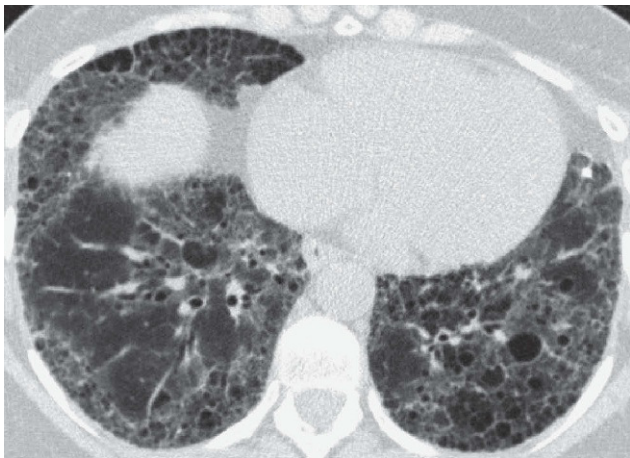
High resolution computerised tomography (HRCT) of patient 1 thorax that shows a peripheral micro cystic pattern that predominates in the bases, with honeycomb and cystic images as well as traction bronchiectasis.
